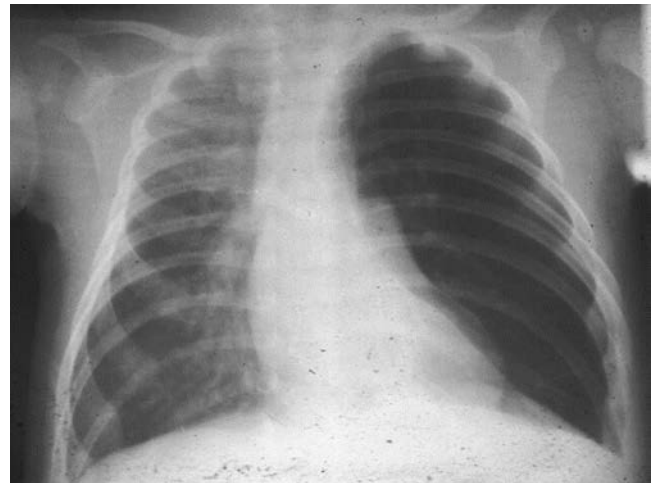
An end-expiration chest x-ray, demonstrating left-sided air trapping by a radiolucent bronchial foreign body. (Courtesy Dr. Peter Masiakos, MD, Department of Surgery, Massachusetts General Hospital, Boston, MA.)
